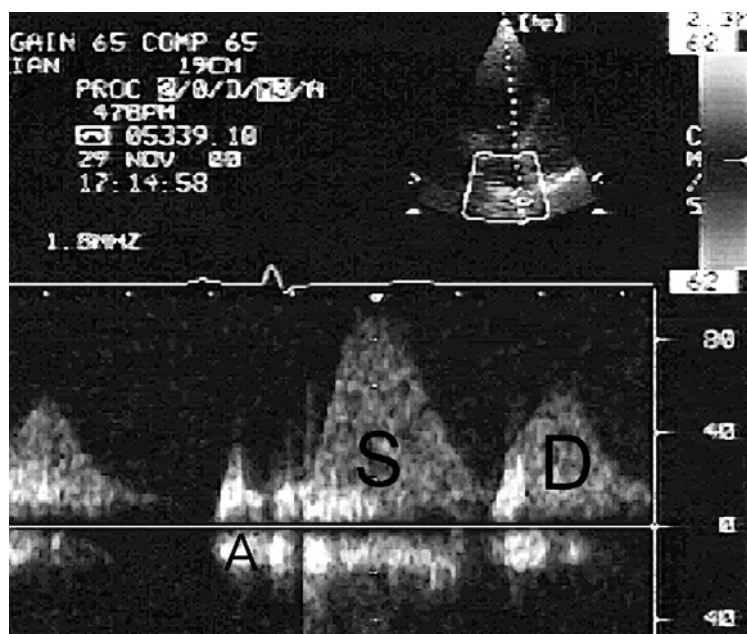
Pulsed Doppler recording of pulmonary venous flow (PVF) measured from right superior pulmonary vein. The components of PVF pattern are systolic (S), diastolic (D) and atrial reverse (A) flow. The measured parameters of PVF were peak velocities, time-velocity integrals of forward PVF flow and durations of atrial reverse flow and diastolic deceleration time (see text).
